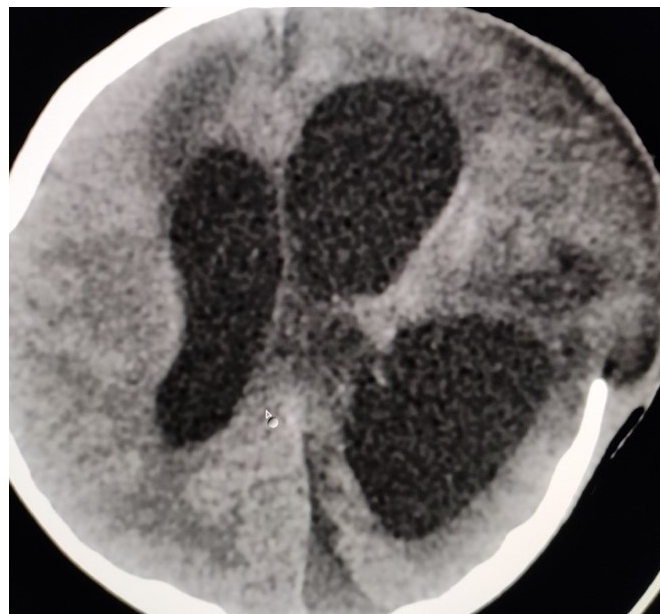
Computed Tomography of brain showing hydrocephalus.
